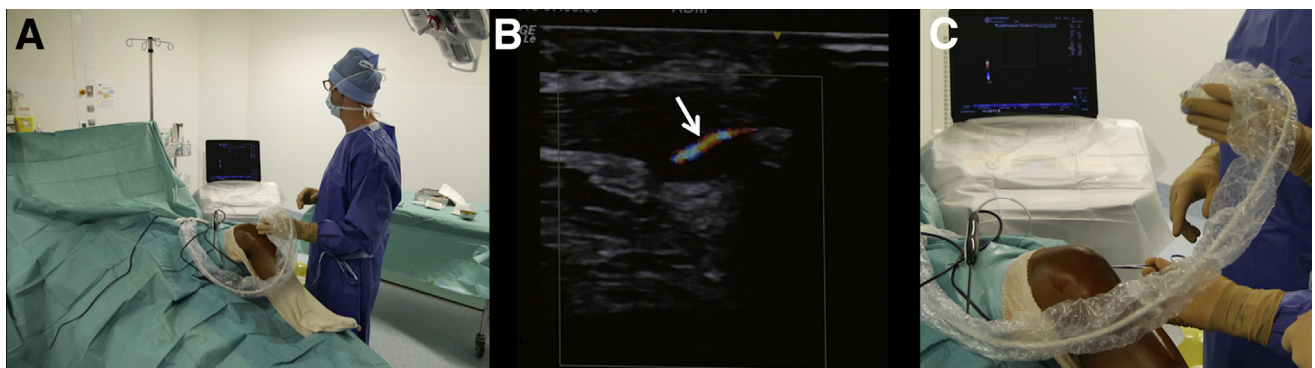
Left knee. (A) Preoperative ultrasound B-mode imaging is performed by the radiologist. (B) Color Doppler mode is used to identify neovascularization (arrow) in contact with the patellar tendon. (C) The neovascularization area is marked on the skin.
